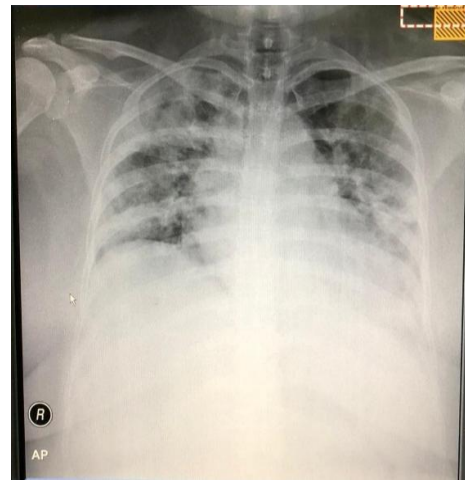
Chest X-ray upon arrival in the ER.
